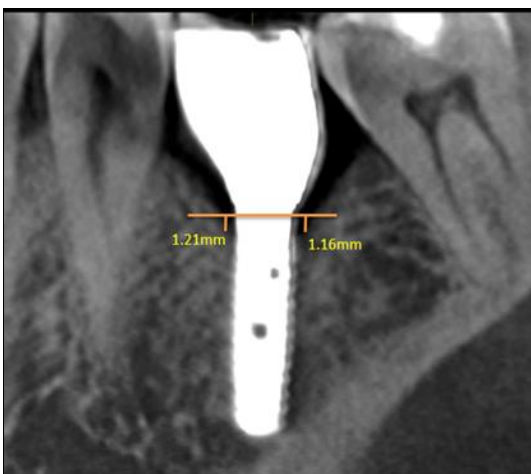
CBCT after 9 months
